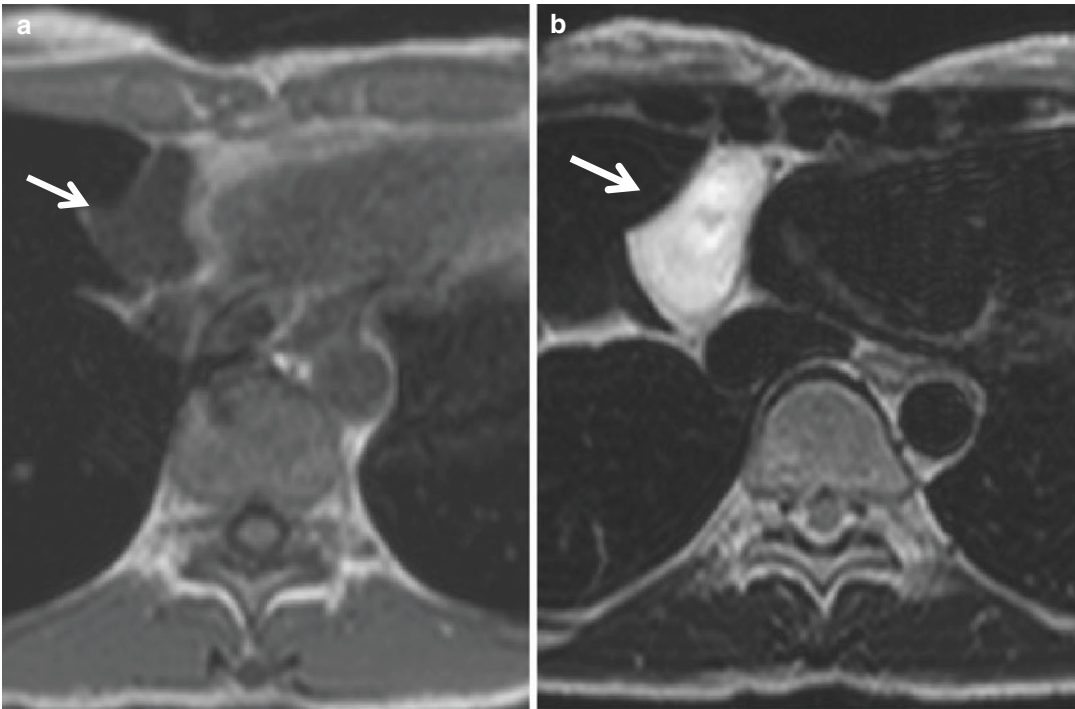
Pericardial cyst. The right cardiophrenic angle is the most common site of pericardial cyst. The cyst typically shows low signal intensity on T1-weighted image (a) and high signal intensity on T2-weighted MR image (b) (arrows)
